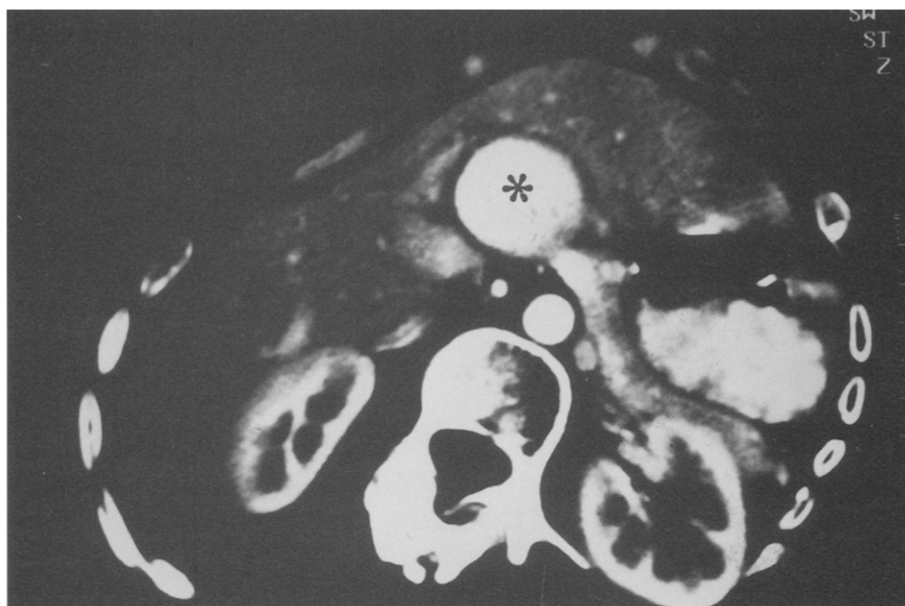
Abdominal computed tomograph: large hepatic aneurysm (*star*).
